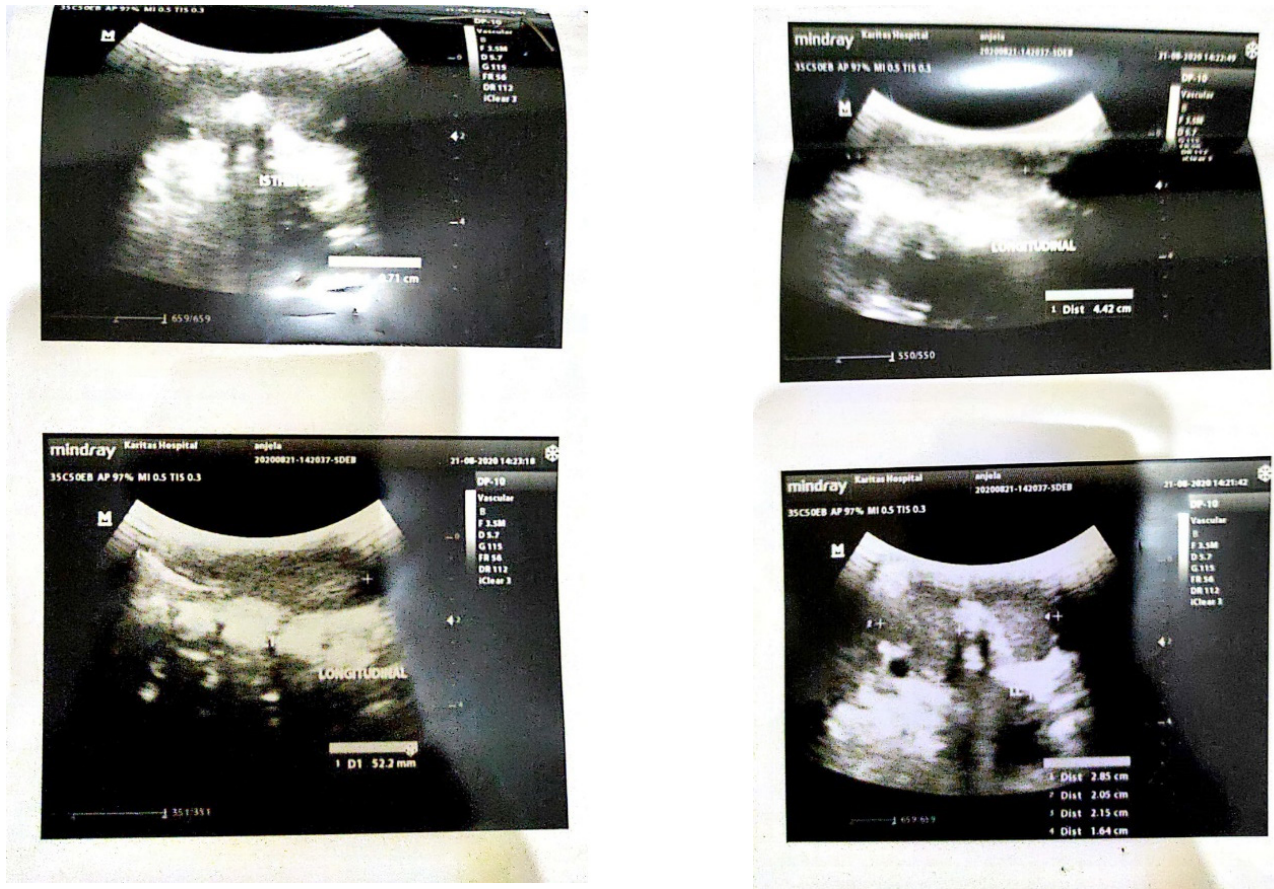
Thyroid ultrasound results using a curved probe
